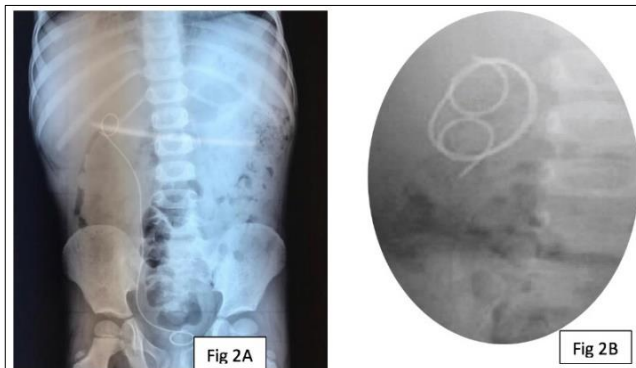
2A) Immediate postoperative X-ray showing properly placed DJ stent; 2B) Image from C-arm monitor showing DJ stent migrated into renal pelvis.
